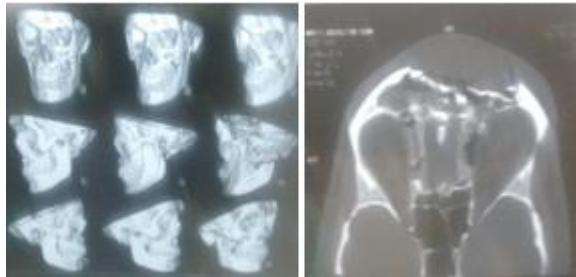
(b): CT facial bone showing depressed Frontal bone involving outer sinus table
